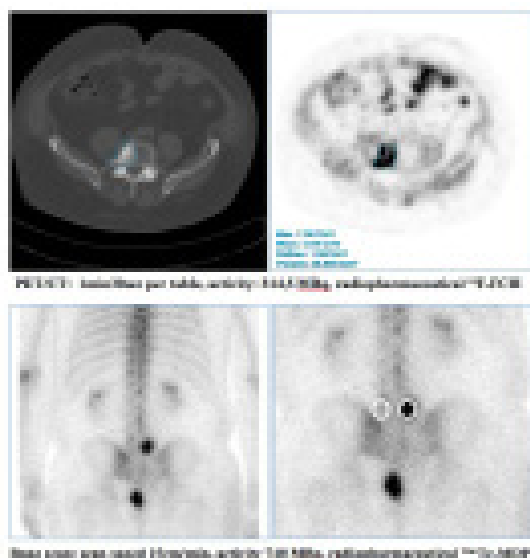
^{99m}Tc -MDP BS and ^{18}F -FCH PET/CT scans in prostate cancer patient.
